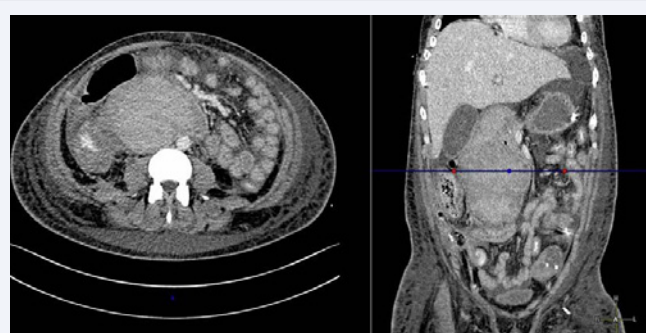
2 Intramural duodenal hematoma on CT.
